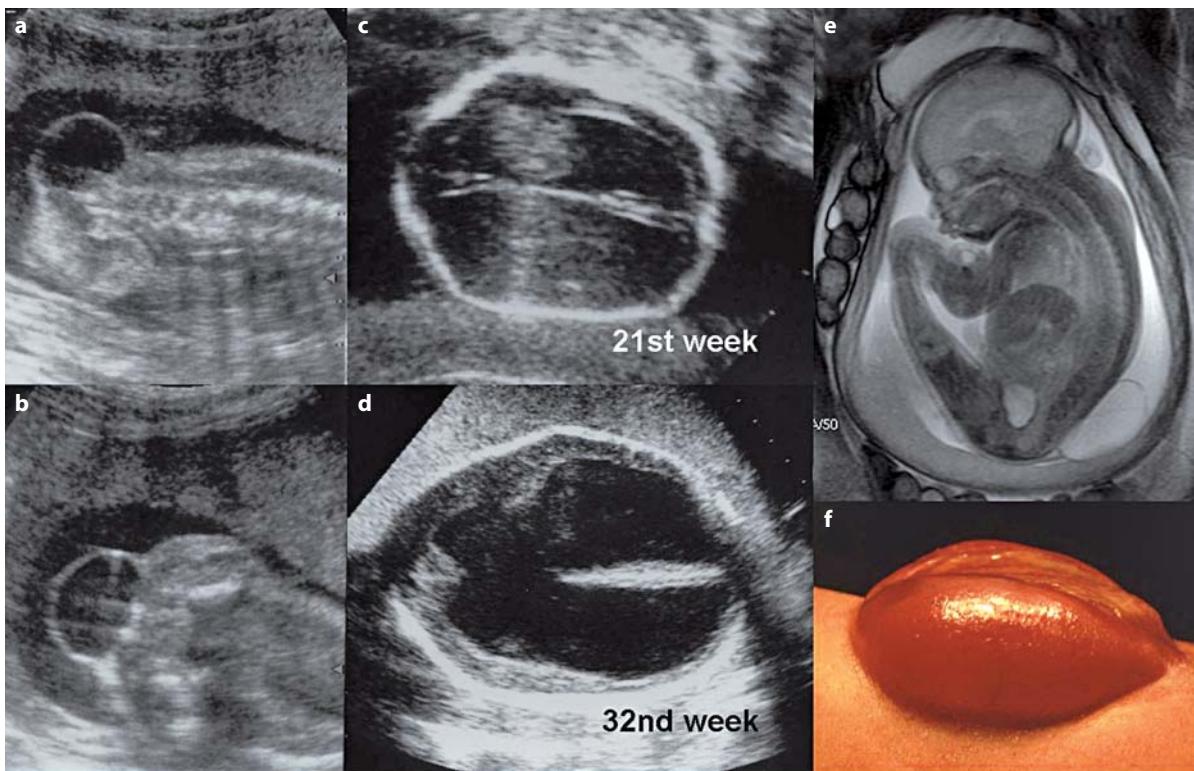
a-f. Prenatal diagnosis of myelomeningocele. a, b Ultrasound demonstration of the spinal defect (AP and lateral views) c, d and evolution of the ventriculomegaly from the 21st to the 32nd gestational week. e T2-weighted fetal MRI demonstrating the spinal malformation; note the absence of ventricular dilatation at this stage. f Clinical appearance of the malformation at birth
